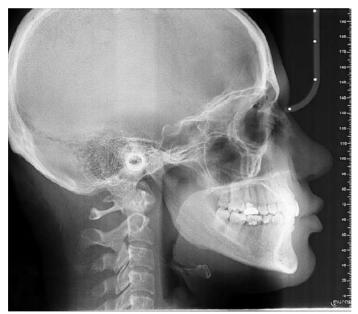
/Female is 22 years old come to our clinic , we noted she have asymmetry in her face and we took her cephlometrics radiography : Based on clinical and manual method we need to
